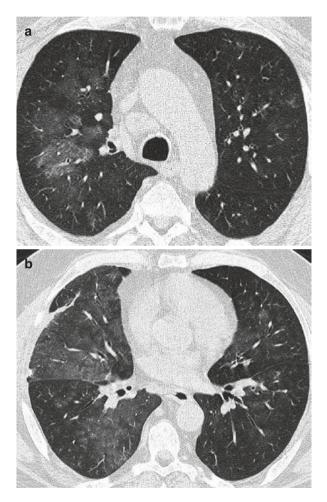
(a) HRCT of the lungs: patchy areas of GGO bilaterally. (b) HRCT of the lungs: GGO areas bilaterally. (c) HRCT of the lungs: patchy GGO areas. (d) HRCT of the lungs: GGO bilaterally
